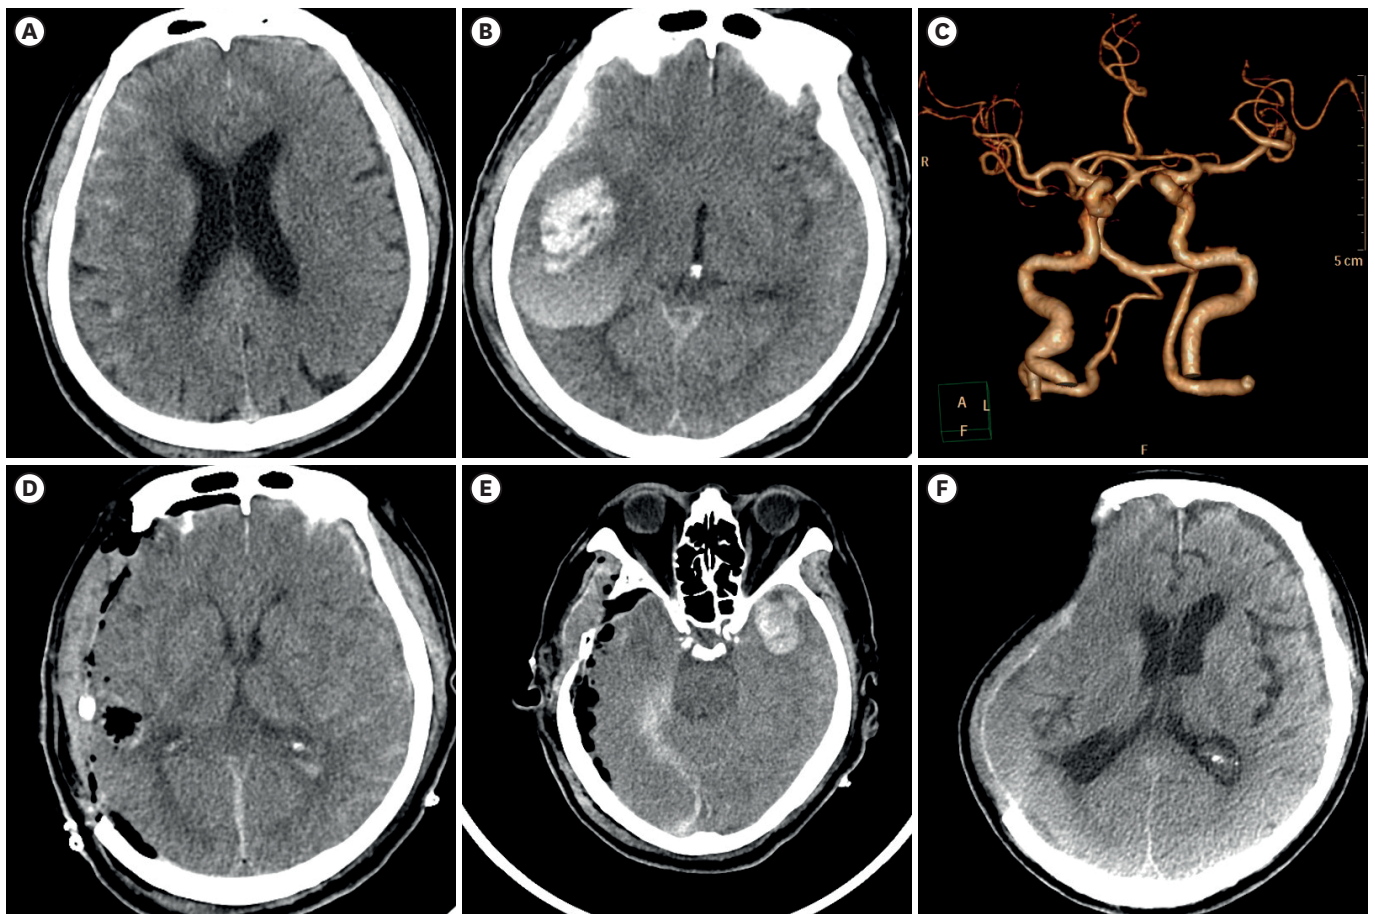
Brain CT scan on admission (A), after 16 hours later (B). CT angiography on admission (C) Postoperative CT showed ipsilateral decompressive craniectomy was done (D) and newly developed intracranial hemorrhage on the contralateral hemisphere (E). Brain CT confirmed the ipsilateral hemisphere was pressed by atmospheric pressure before cranioplasty (F). CT: computed tomography.
